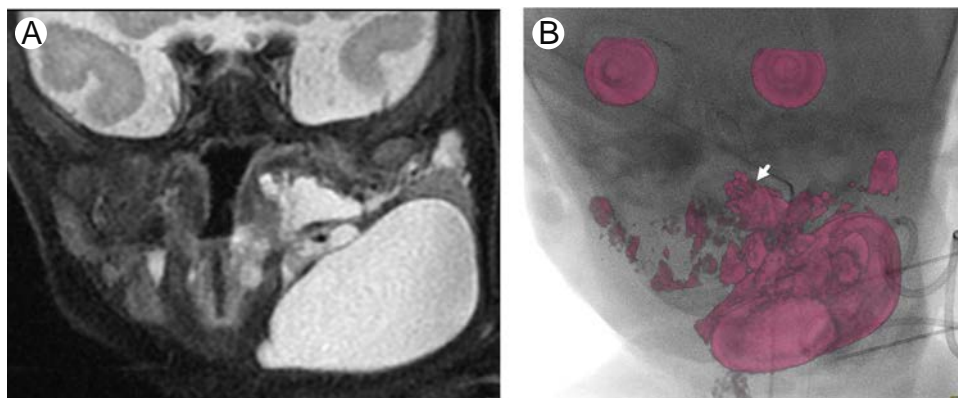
MRI fusion. (A) T2-weighted MRI of a 0-day-old male with a LM surrounding the airway. (B) MRI fusion was critical in insuring doxycycline reached components adjacent to the trachea, arrow. Note 2 drains and multiple access sites used during treatment. (Color version of figure is available online.)
